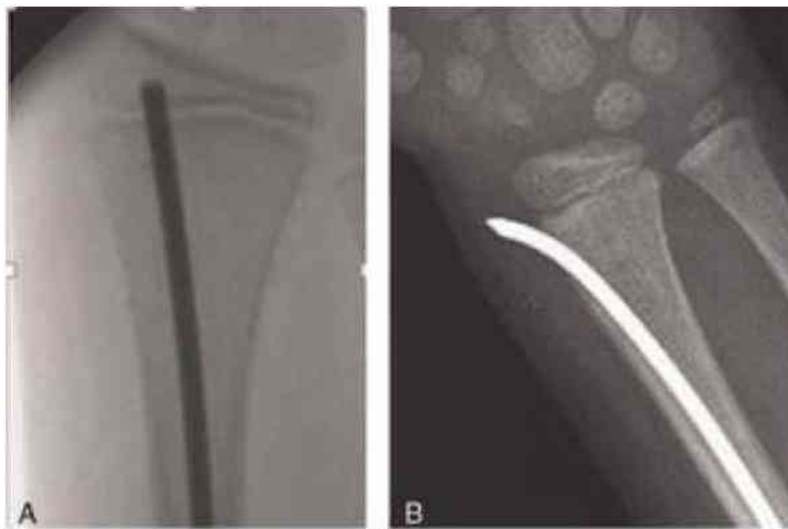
Anteroposterior X-rays of different radial approaches of ESIN techniques
